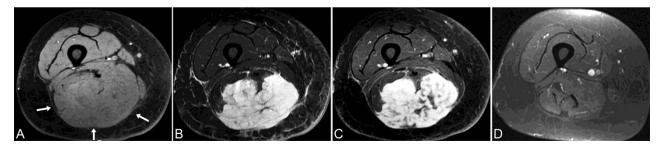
Myxoid liposarcoma in the left thigh of a 35-year-old woman. Pretreatment MRI shows an indistinct soft tissue mass in the posterior compartment of the left thigh with signal intensity that is isointense to the adjacent normal muscle on axial FS T1-WI (A, arrows). The lesion is heterogeneously hyperintense on axial FS T2-WI (B). Postcontrast axial FS TW1-WI (C) shows heterogeneous tumor enhancement. Follow-up MRI after treatment with 6 cycles of chemotherapy (D) shows complete resolution of the soft tissue tumor on axial postcontrast FS T1-WI.
